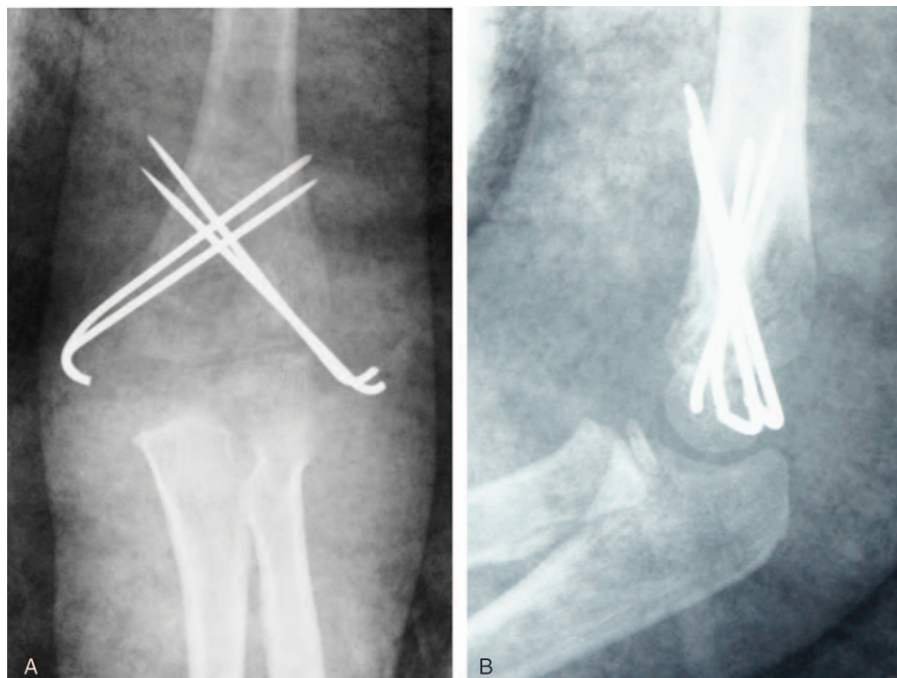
(A, B) Postoperative anteroposterior and lateral radiographs of the left elbow. Double cross-pinning provided stability for the intercondylar fracture of the elbow.
